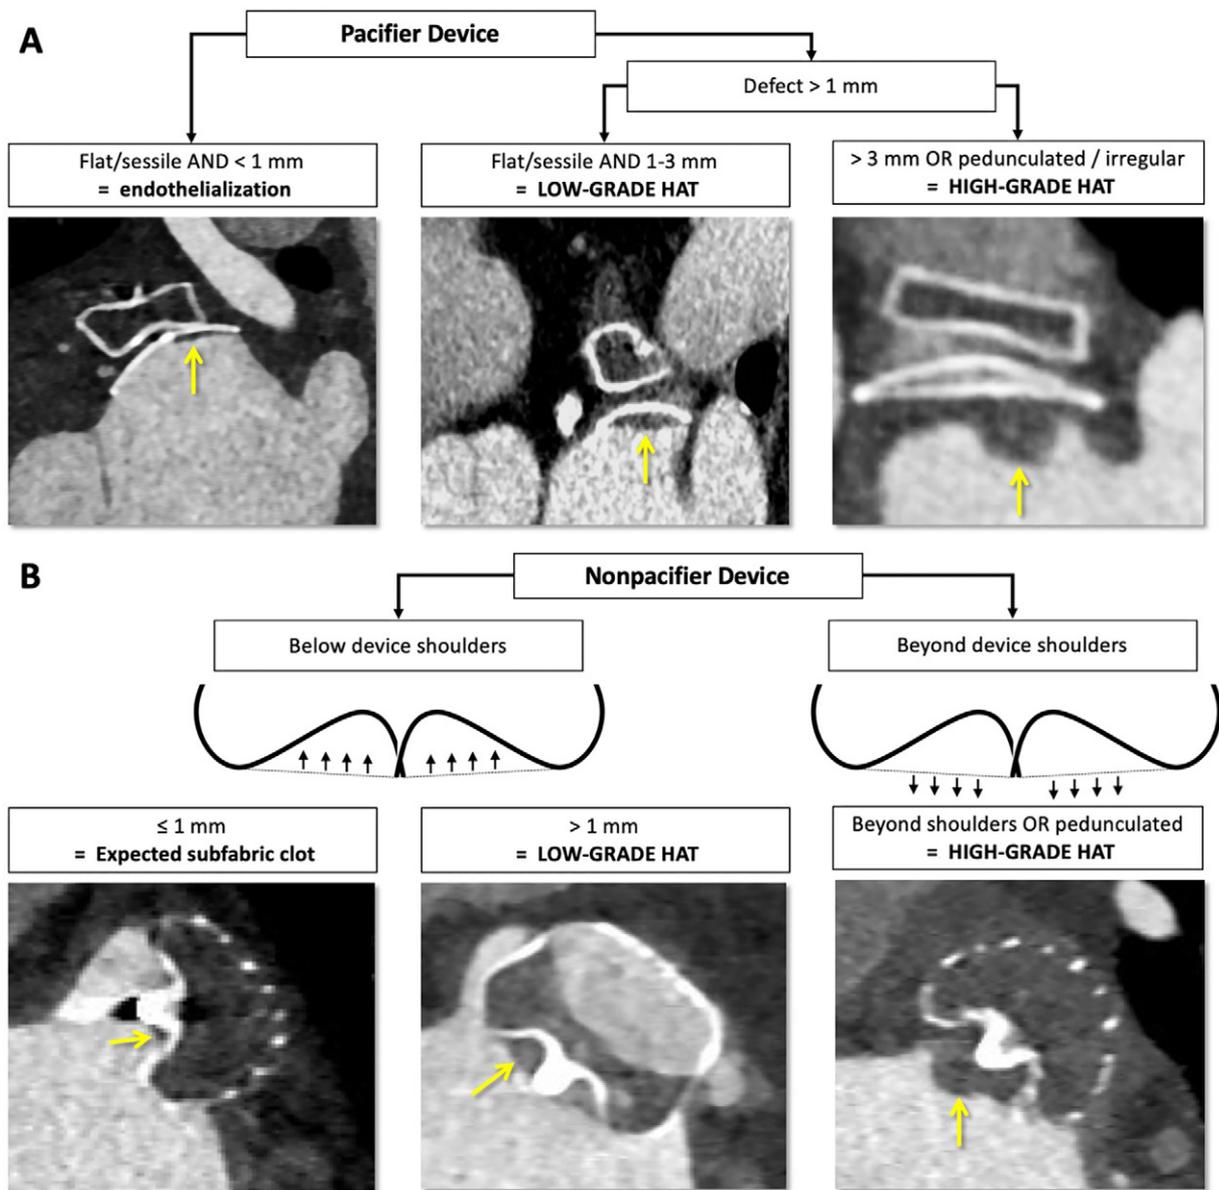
CT interpretation algorithms for the analysis of hypoattenuation thickening (HAT; arrows). (A) Interpretation algorithm applicable to pacifier devices. (B) Interpretation algorithm applicable to nonpacifier devices.
